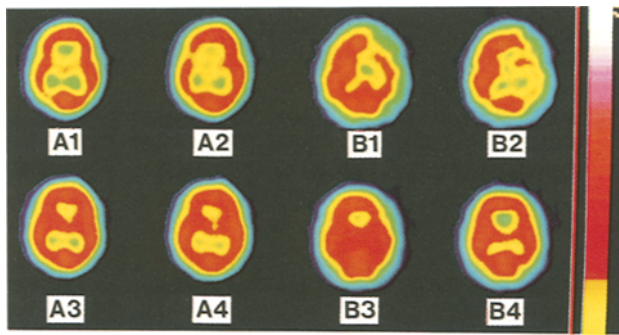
A 1, A 2 and B 1, B 2: SPECT before recovery of useful vision in patient A and B respectively. A 3, A 4: 3 days and B 3, B 4: 6 days after the first SPECTs respectively, all being normal. Methods: Technetium-99m hexamethyl-propyleneamine oxime 15 mCi Cerebral Blood Flow Planar (Elscont apex 609 RG), slice thickness: 6 mm
